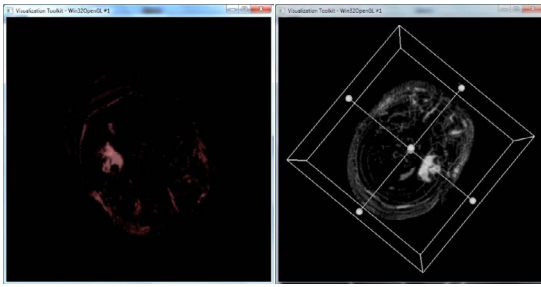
Volume rendering of MRI segmented data (left) and volume rendering with Maximum Intensity Projection and Depth peeling
